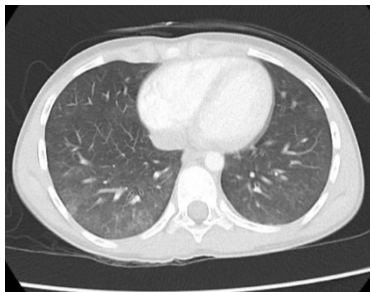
CT scan showing bilateral symmetrically distributed ground glass and small intrapulmonary nodules consistent with fat embolism syndrome.
